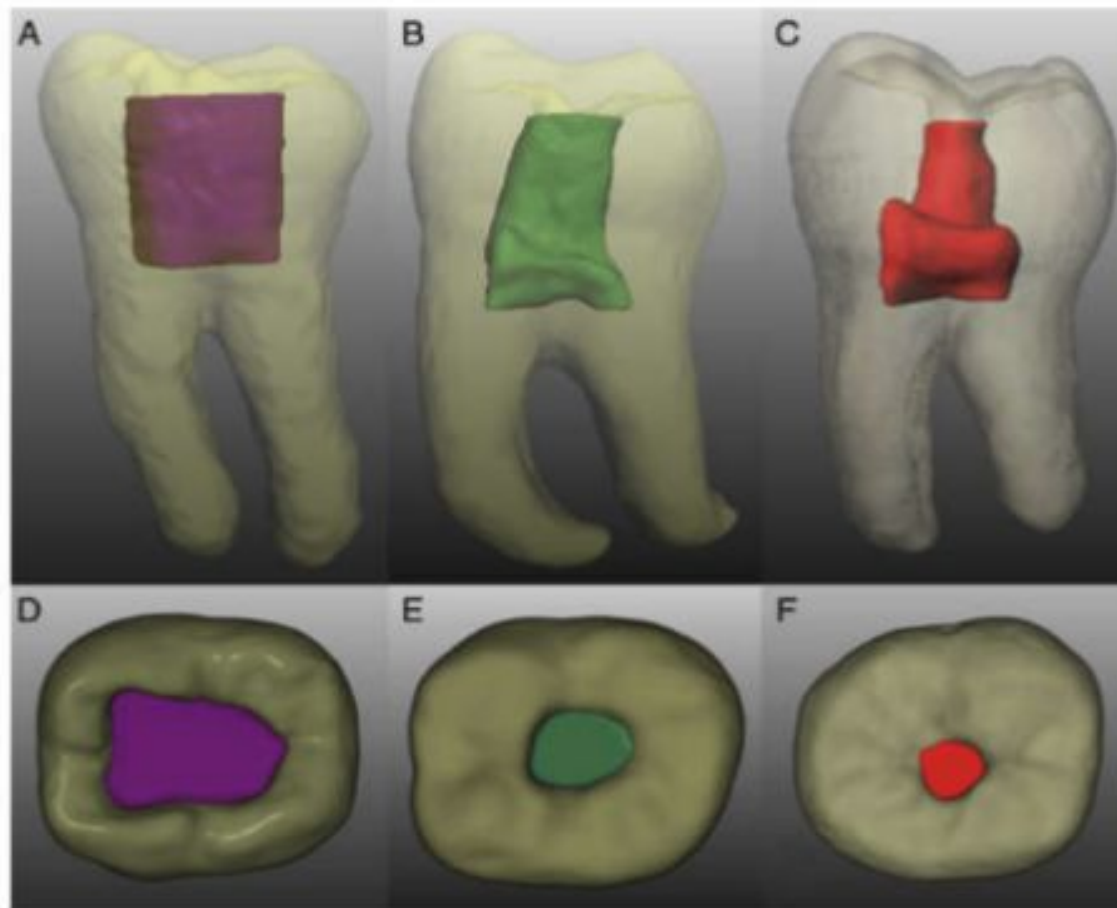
(A–F) CBCT 3-dimensional reconstructions and segmentations of lower molars prepared with different access cavity designs in (A–C) the sagittal view and (D–F) the axial view at the occlusal surface. (A and D) A traditional access cavity (purple), (B and E) conservative access cavity (green), and (C and F) ultraconservative “ninja” access cavity (red) are segmented on CBCT reconstructions.
